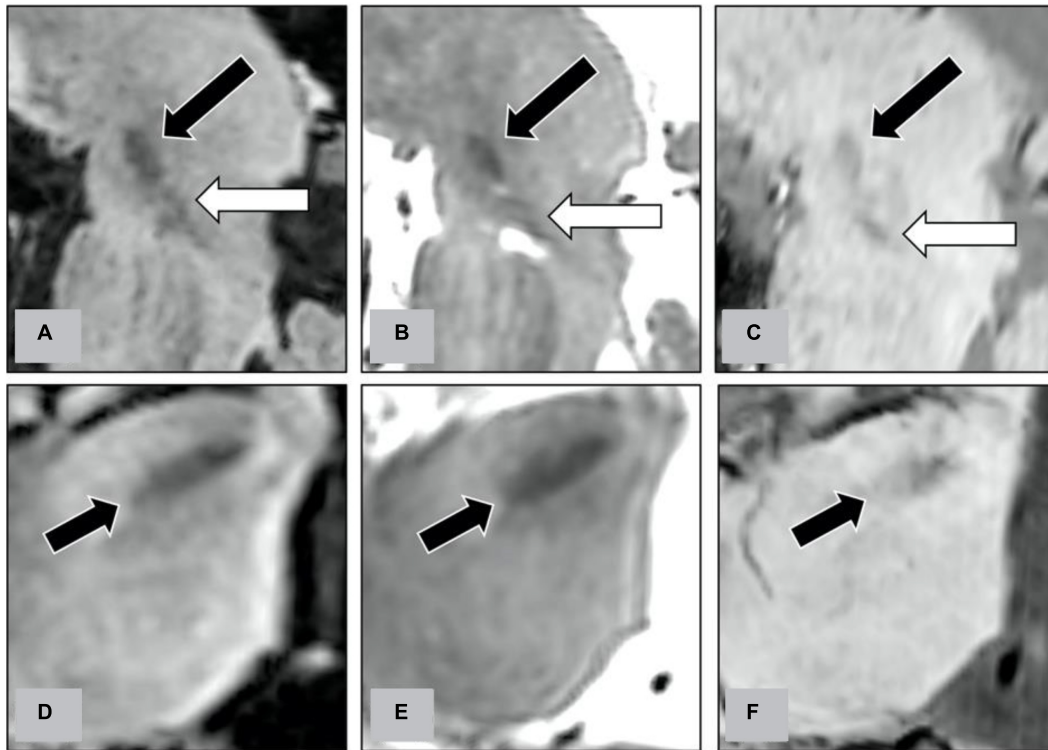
Along the trajectory of STN-DBS electrodes, we reconstructed the oblique sagittal images on FLAIR (A), T2WI (B), and SWI (C). On the oblique sagittal images, we evaluate the delineation between STN (indicated by black arrows on figures) and substantia nigra (indicated by white arrows). We also reconstructed the oblique axial images perpendicularly to the trajectory at the level of the STN on FLAIR (D), T2WI (E), and SWI (F). On the oblique axial images, we evaluate the delineation of the lateral border of STN (indicated by black arrows).
